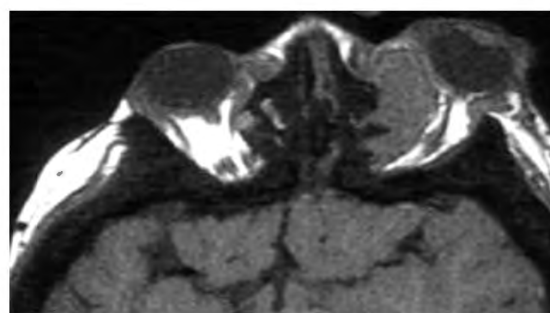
In the left orbital extraconal space, just in the vicinity of laminae papiracea, a hypointense ovoid lesion displacing rectus muscles and optic nerve to lateral is seen (axial SE T1W MRI section taken from orbital level). Moreover the left eyelid is thickened and seen hypointense. There is evident proptosis on the left side.
